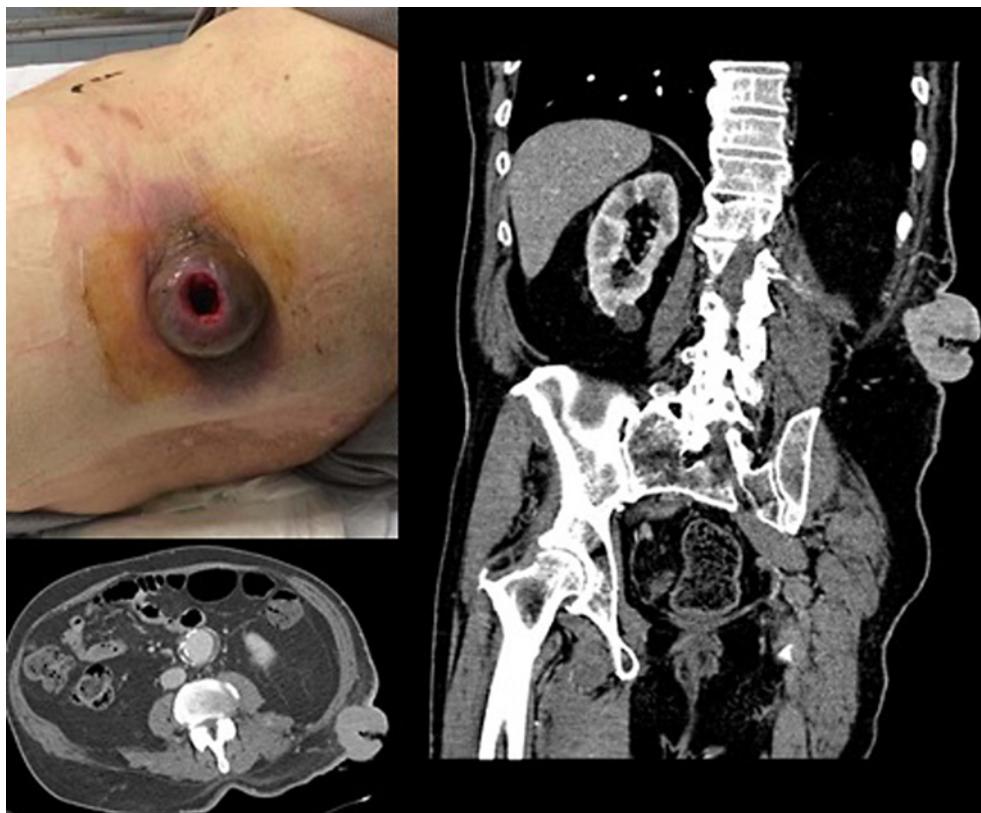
Top left image: cutaneous ulcerated lesion. Bottom left image: skin metastasis as seen on portal venous phase contrast-enhanced CT. Right image: skin metastasis, arterial phase CECT. CT, computed tomography.
